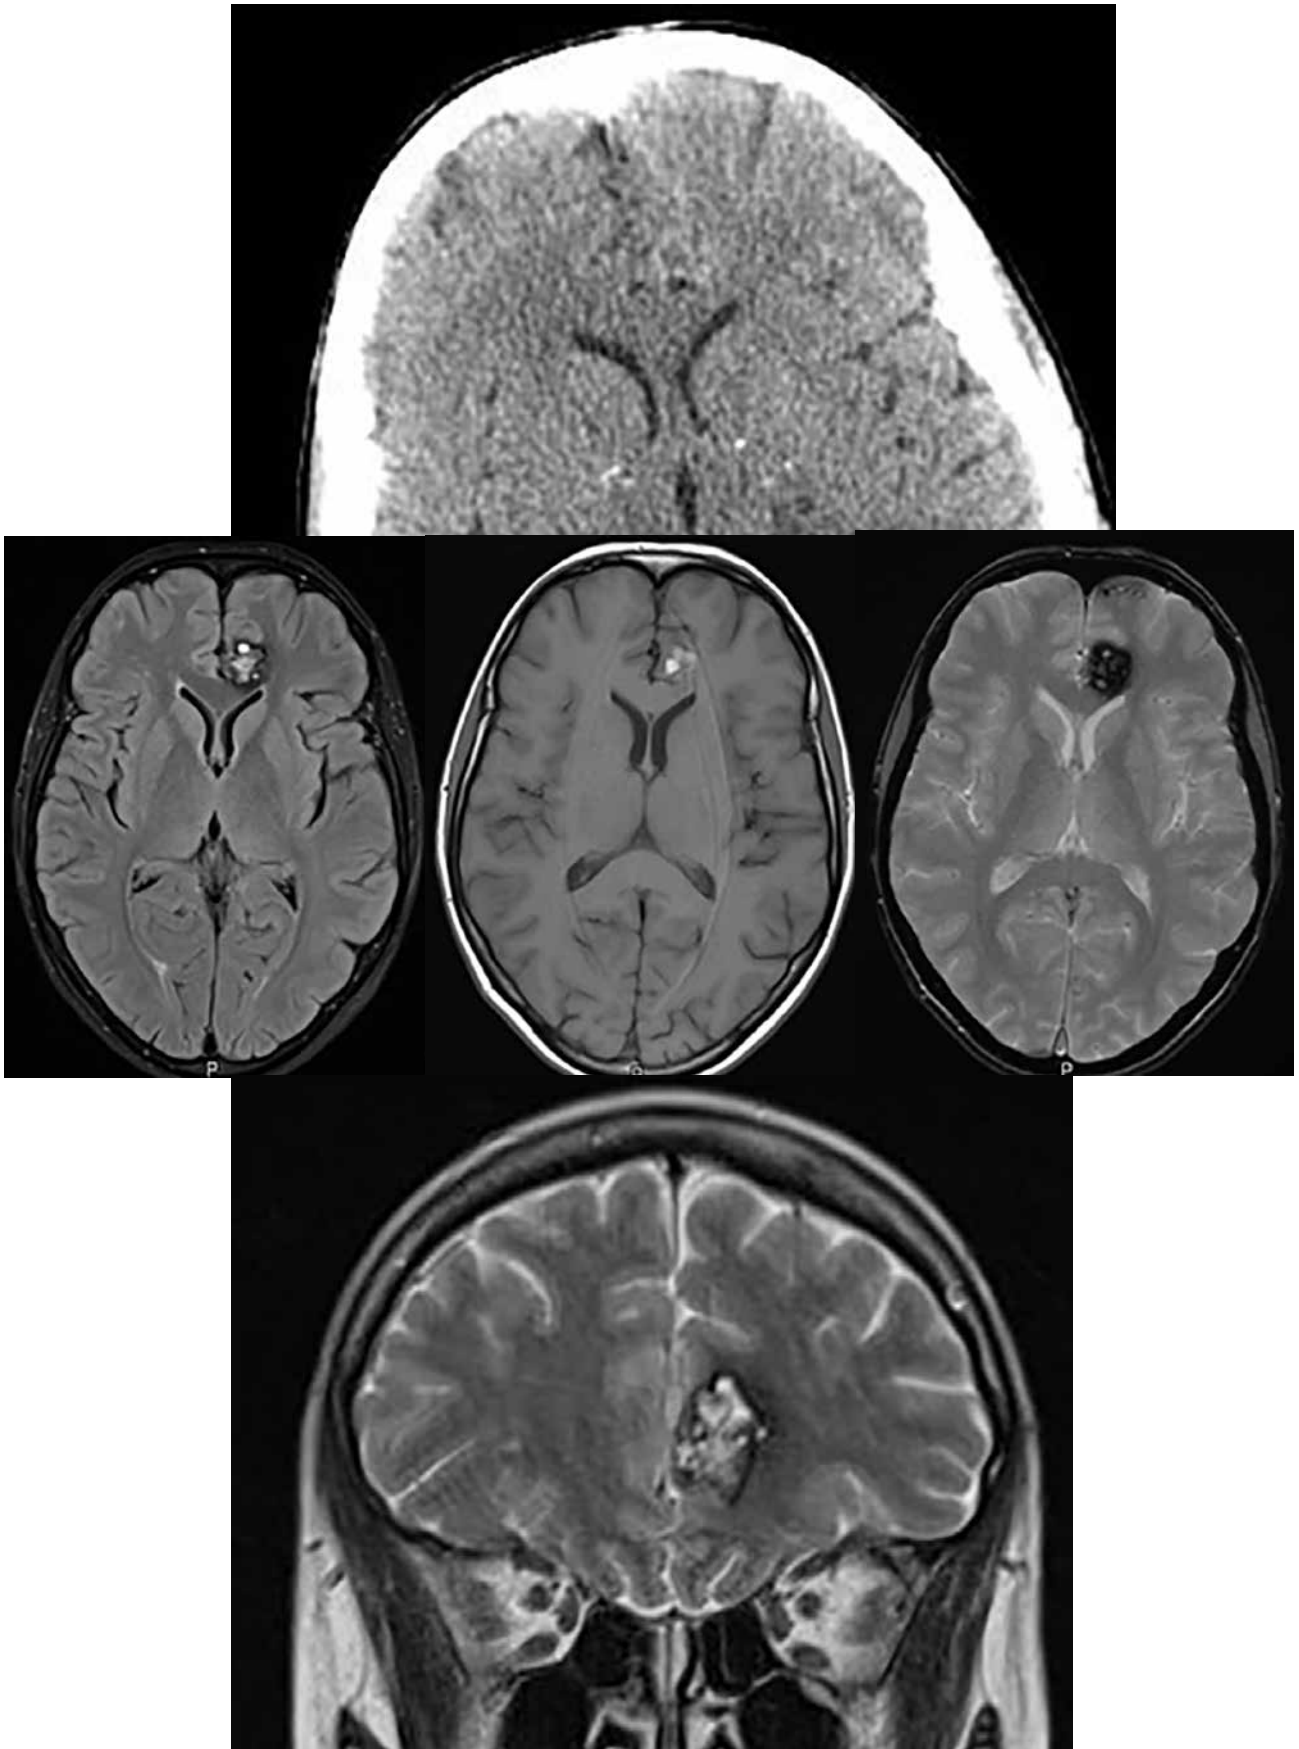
Cavernoma at the left frontal lobe (a - axial CT; MRI: b - T2W/FLAIR axial; c - T1W axial; d - T2W fl2 hemo axial; e - T2W coronal).
